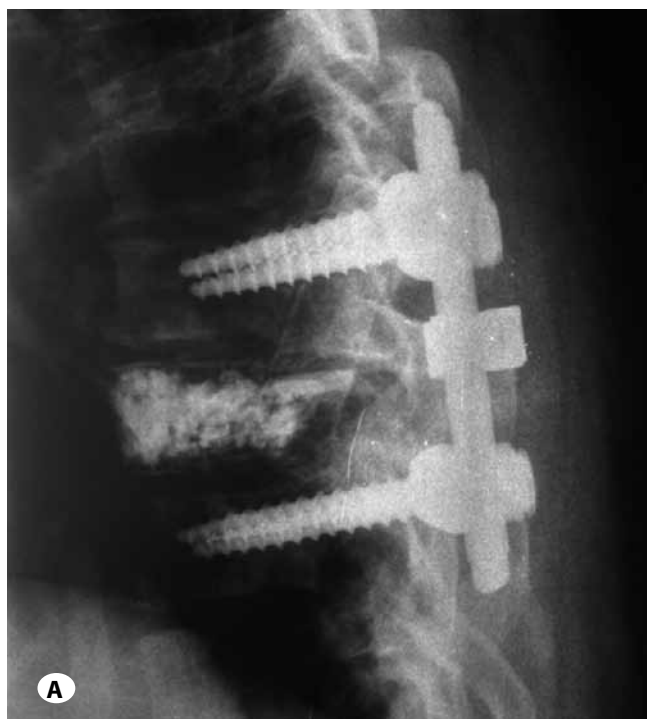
A) Postoperative x-ray spine of the thoracic region showing vertebroplasty and short segment posterior stabilization and fusion. B) Postoperative x-ray spine of the thoracic region showing vertebroplasty and short segment posterior stabilization and fusion.
